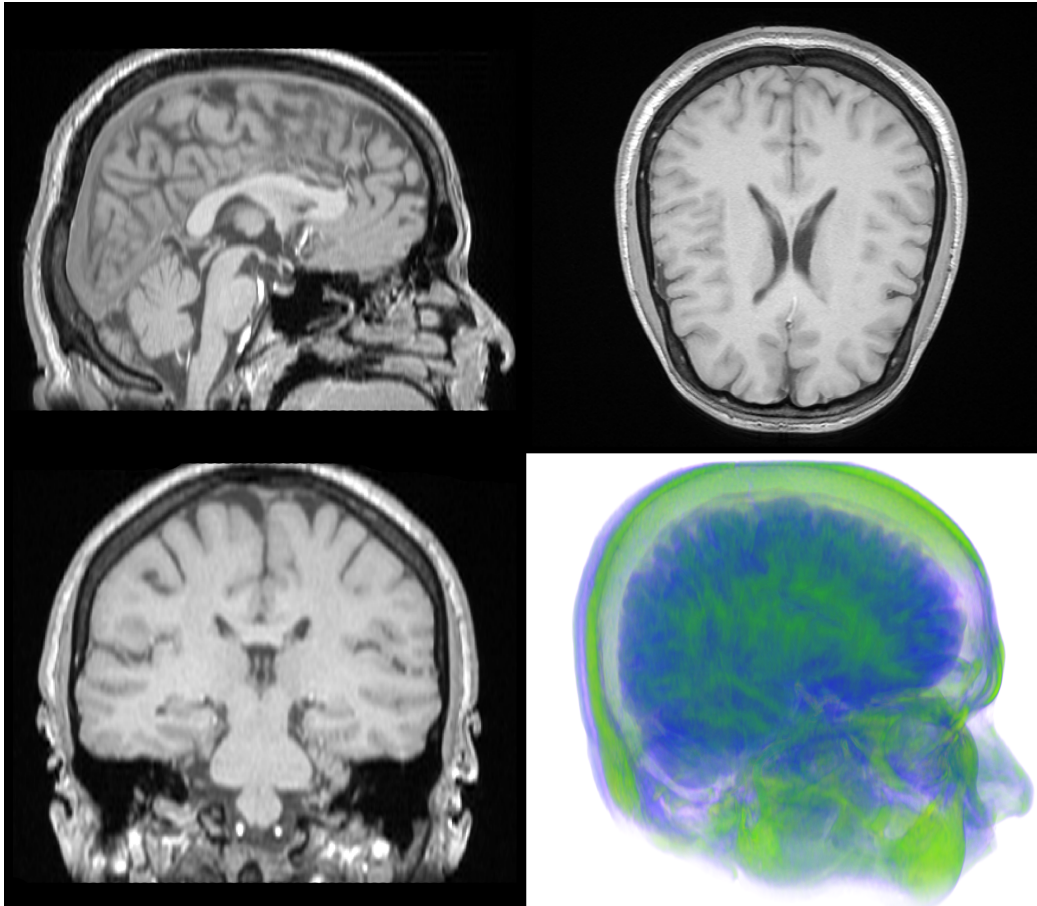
Sagittal and Coronal MRI slices of a healthy brain from the patient described in §4.2.1.1.2.
